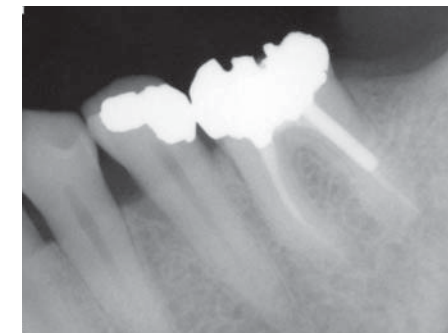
Radiographic examination demonstrates a short residual root trunk between the fracture and the entrance to the buccal furcation. Performance of crown-lengthening osseous surgery would result in a significant buccal furcation involvement on the first molar.
